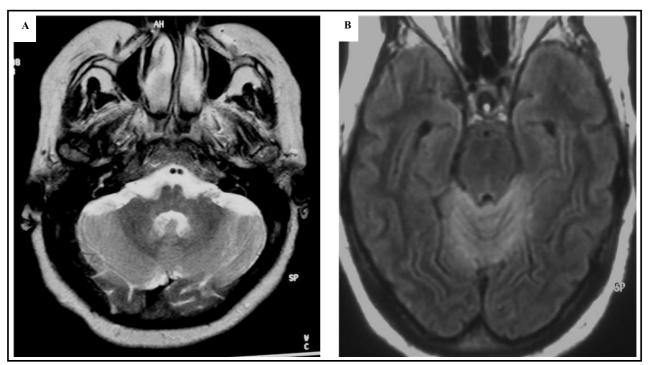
Axial T2 (a) and FLAIR (b) weighted images show diffuse cortical increased signal intensity and swelling in both cerebellar hemispheres and vermis.
